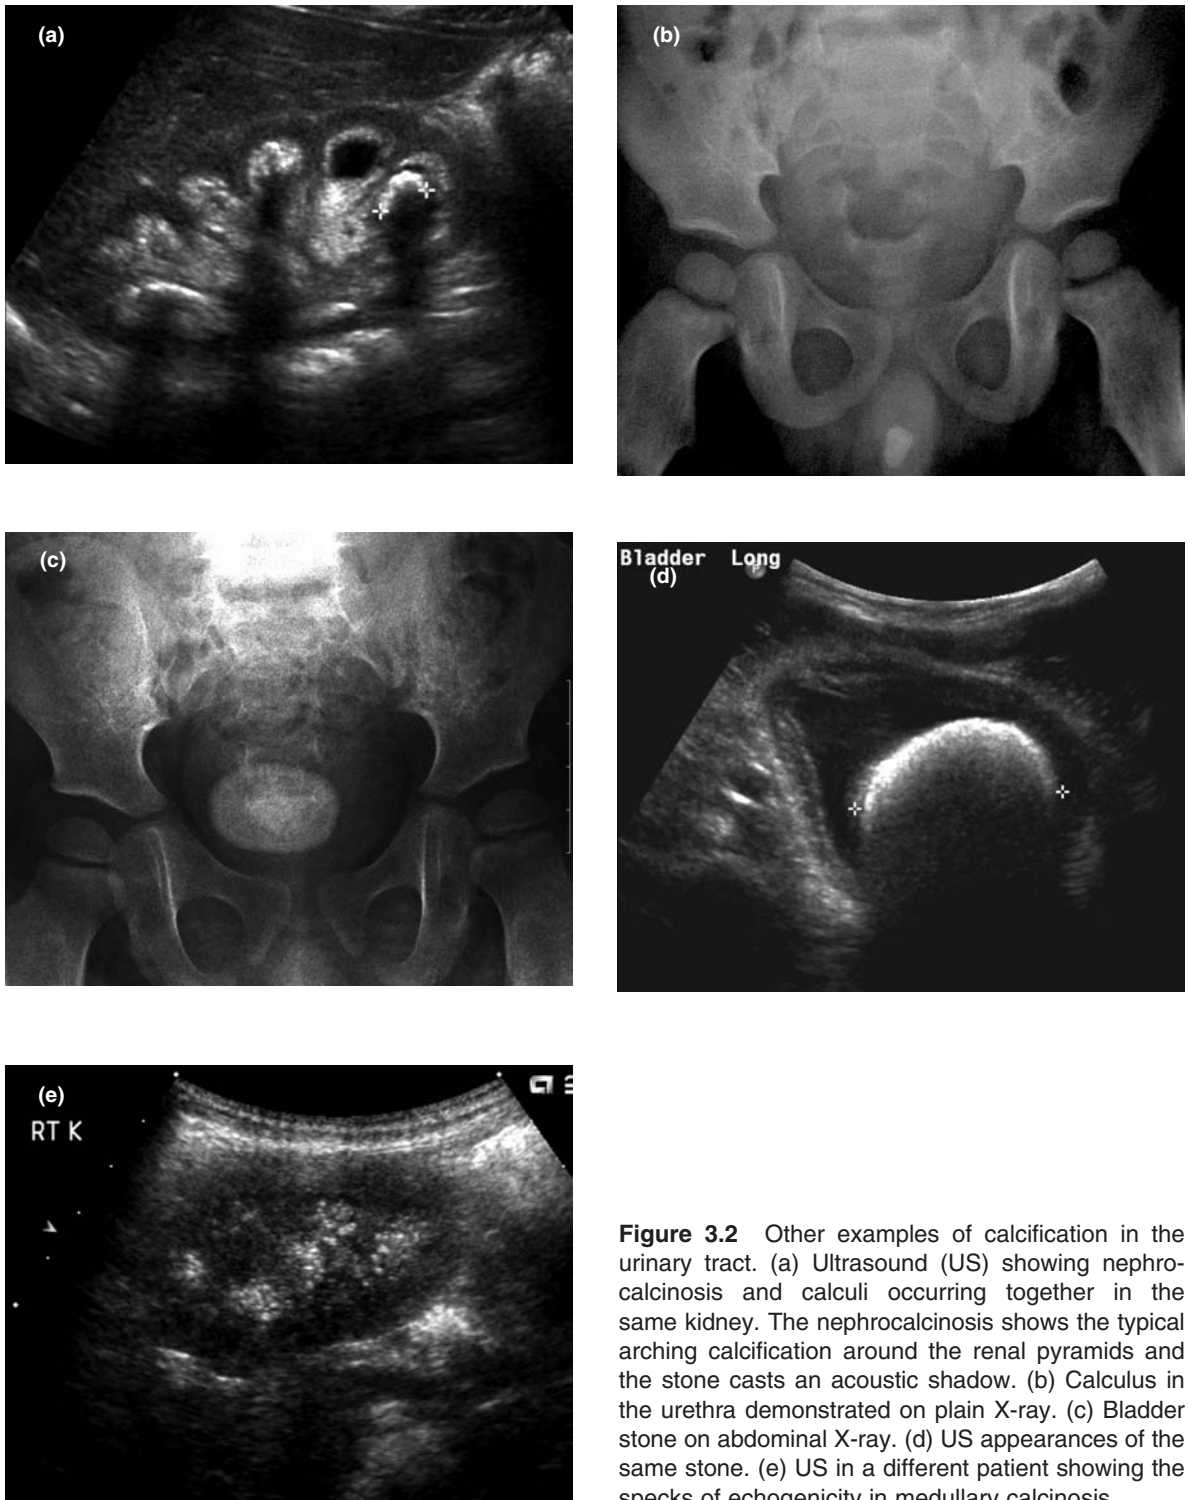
Other examples of calcification in the urinary tract. (a) Ultrasound (US) showing nephrocalcinosis and calculi occurring together in the same kidney. The nephrocalcinosis shows the typical arching calcification around the renal pyramids and the stone casts an acoustic shadow. (b) Calculus in the urethra demonstrated on plain X-ray. (c) Bladder stone on abdominal X-ray. (d) US appearances of the same stone. (e) US in a different patient showing the specks of echogenicity in medullary calcinosis.
